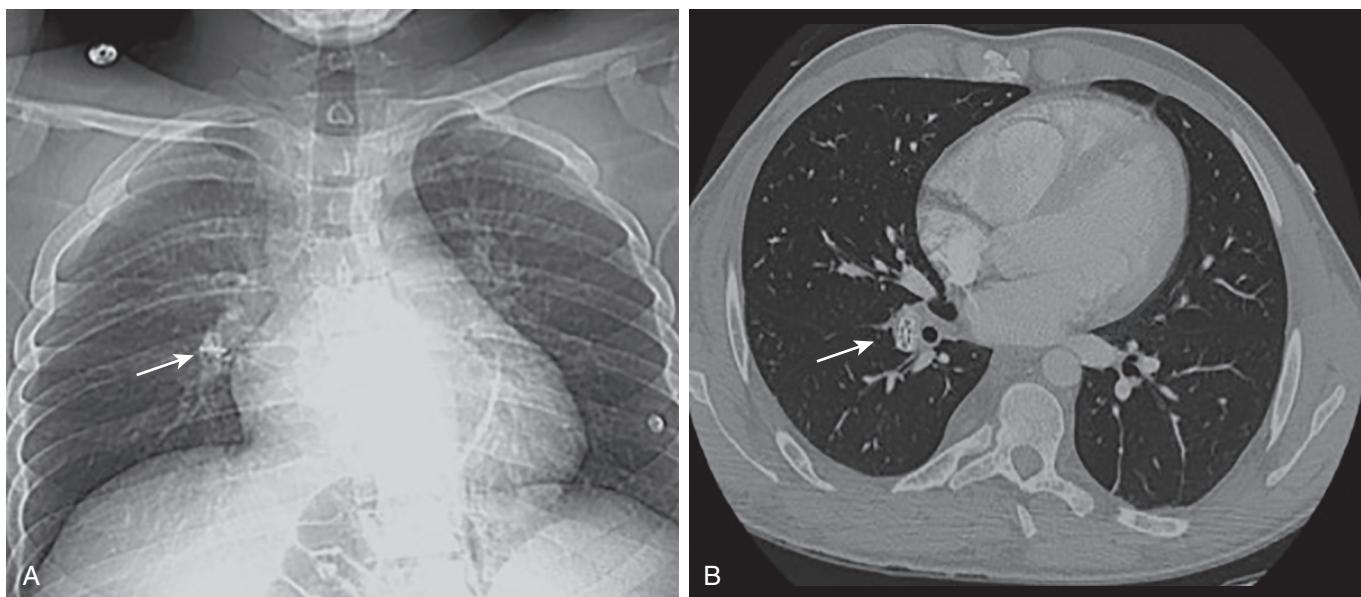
Embolization of an occlusion plug (arrows) from the right internal iliac vein into the pulmonary circulation, seen on chest X-ray (A) and CT scan (B).
